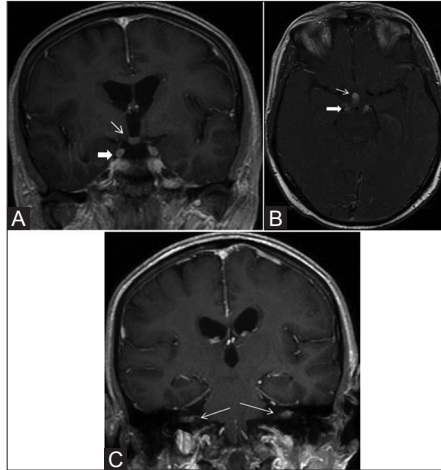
Coronal (A) and Axial (B) contrast-enhanced T1-weighted MR image reveals diffuse enhancement and thickening of the cisternal segments of bilateral oculomotor nerves (thick arrow) and infiltration of the hypophyseal infundibular stalk (thin arrow). Coronal (C) contrast-enhanced T1-weighted MR image demonstrates diffuse enhancement and thickening of the bilateral facial and vestibulocochlear nerves (arrow).
